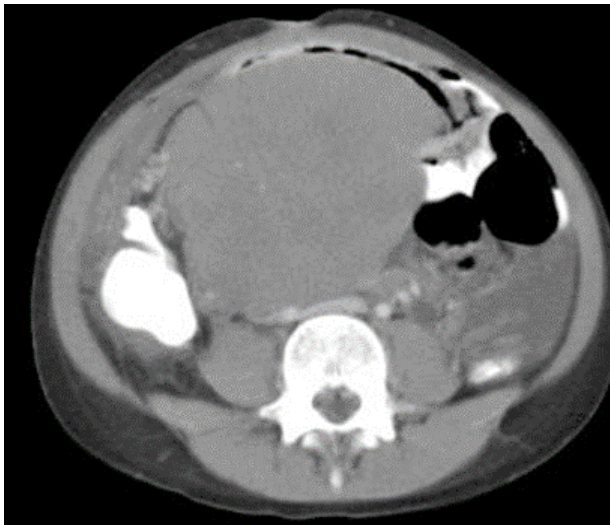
Repeat CT scan at approximately the same level as in Fig. 2.
